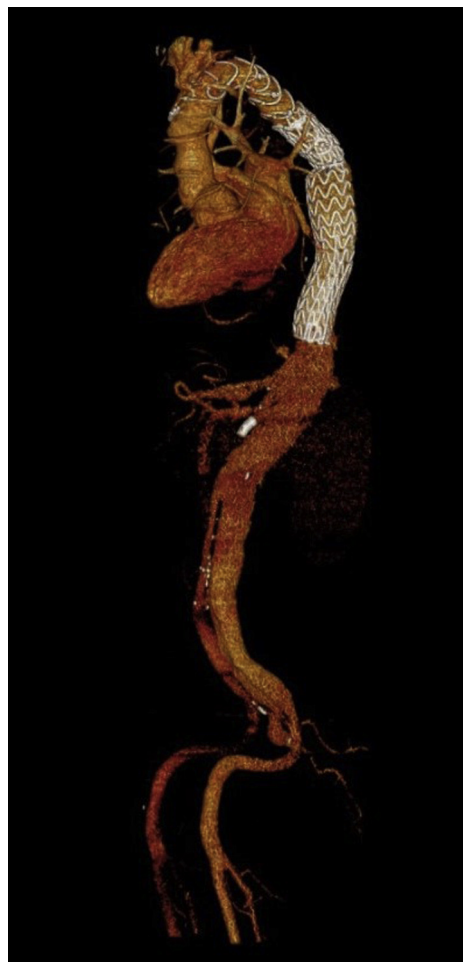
Three-dimensional reconstructed computed tomography angiography image 6 months postoperatively. Note the re-expanded proximal part of the stent graft and the open reconstruction up to the infrarenal aorta (where the dissection flap becomes visible again).
